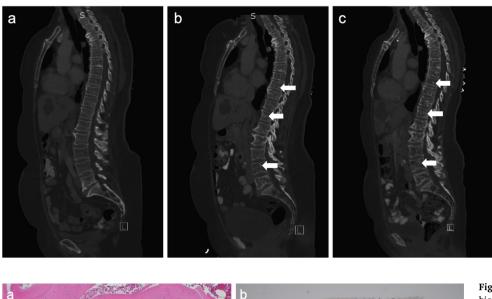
(a) Sagittal CT image 12 months prior to recurrence obtained from outside medical institution, where no sclerotic lesions are visible. (b) Sagittal CT image at the time of diagnosis of recurrence, showing innumerable punctate sclerotic lesions throughout the spine. Examples of sclerotic foci are indicated with white arrows. (c) Sagittal CT image demonstrating stable disease 2 years following the initiation of letrozole therapy. Examples of sclerotic foci are indicated with white arrows.
